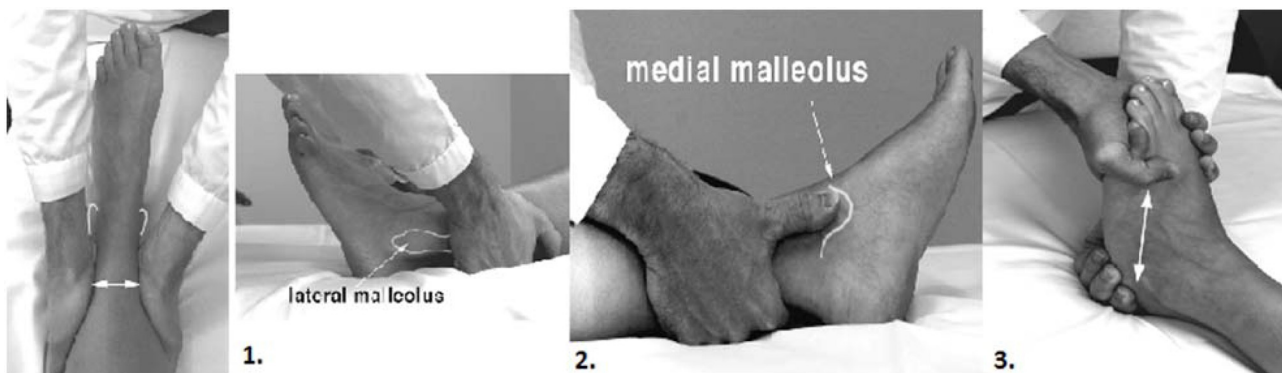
The Bernese ankle rule. The rules are positive and indicate the need for radiography if one of these steps caused pain. (1) Indirect fibular stress: the malleolar fork is compressed approximately 10 cm proximally to the fibular tip. (2) Direct medial malleolar stress: the thumb is pressed flat on the medial malleolus. (3) Compression stress of the midfoot and the hindfoot: one hand fixes the calcaneus in a neutral position and the other hand applies a sagittal load on the forefoot, so that the midfoot and hindfoot are compressed.
